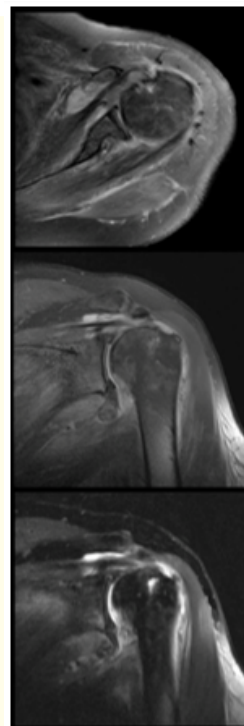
Left Shoulder MRI after 1 month, showing articular effusion, supraspinatus tear, subscapularis tear and capsule distension. Suitable articular congruency.
